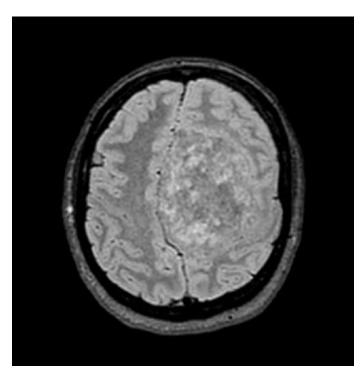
Axial FLAIR image. Extra axial, smoothly contoured, inhomogeneous signal intensity mass, located parasagittal to the left of the falx cerebri. Midline dislocation to the right. Left frontal, and parietal lobes are affected.
